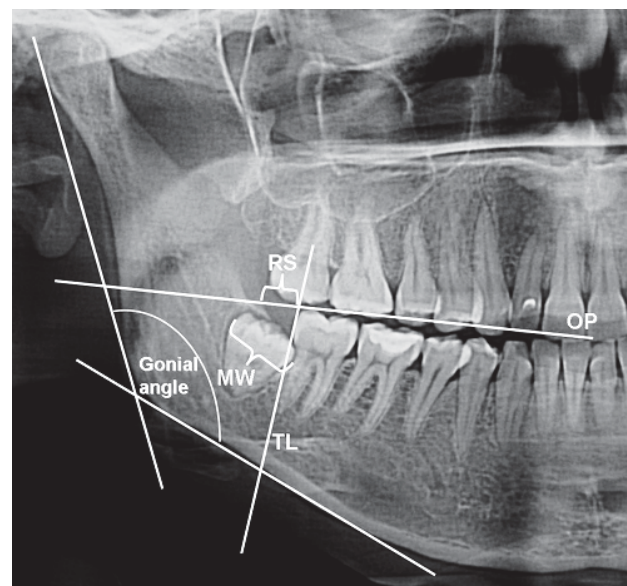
Linear and angular measurements on orthopantomogram
